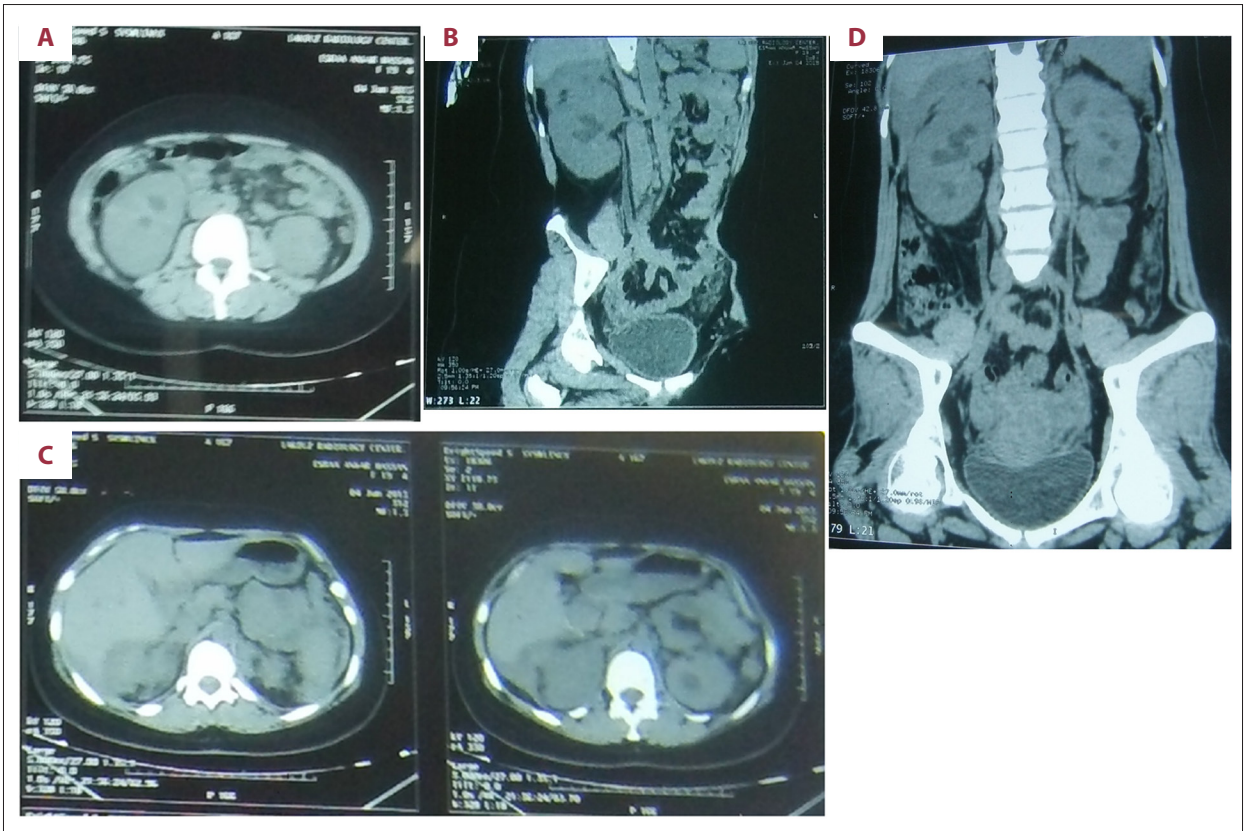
(A, B) Axial and reformatted coronal NECT cuts in the same patient showing bilateral and symmetric early perirenal infiltration (arrow), which gives the appearance of “hairy kidney”. (C) Axial CT scan of bilateral adrenal thickening. (D) Reformatted NECT scan shows bilateral and symmetric infiltration of the renal sinuses, with mild hydronephrosis.
